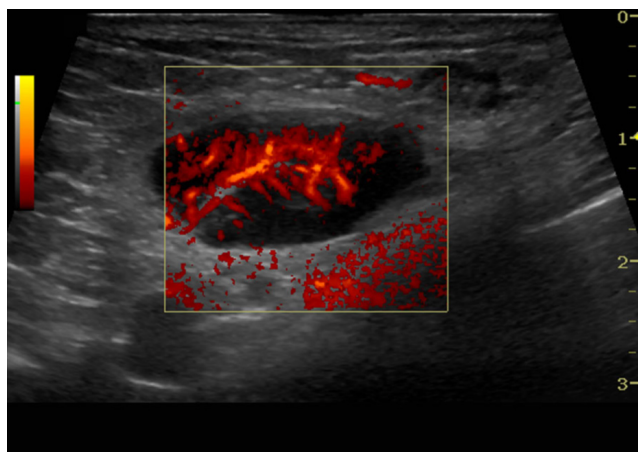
75-year-old woman with primary breast lymphoma. Color Doppler image of the same axillary lymph node demonstrates increased vascularity with increased cortical flow.
